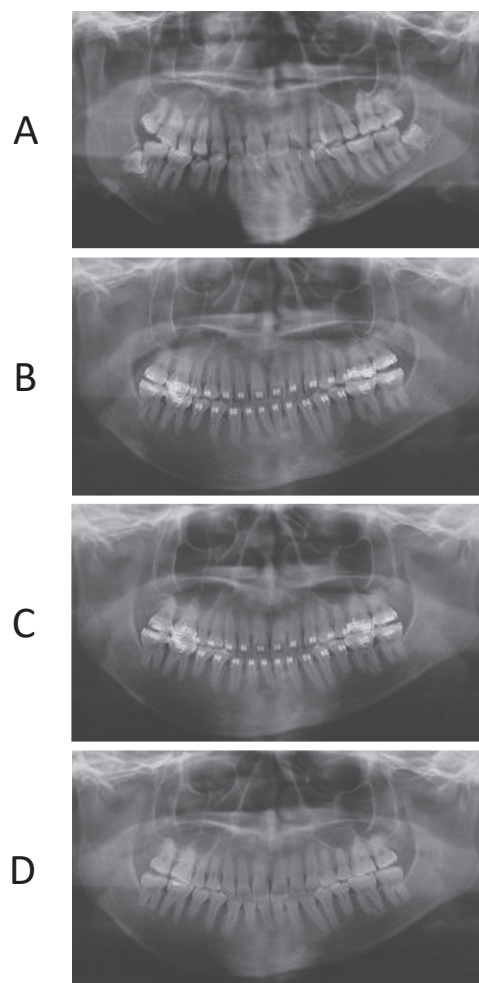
Panoramic radiographs. A, pre-treatment (17 years 6 months old); B, pre-orthognathic-surgery (20 years 9 months old); C, post-active treatment (22 years 8 months old); D, post-retention (24 years 9 months old).
